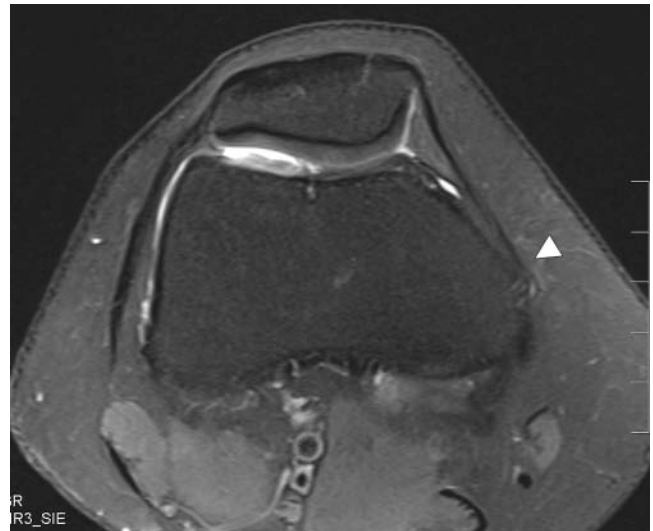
A transverse T2-weighted fast spin-echo MRI of the knee, obtained immediately inferior to the adductor tubercle. Arrowhead indicates normal medial patellofemoral ligament femoral insertion.
